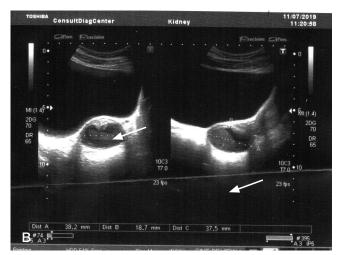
Transabdominal ultrasound examination: A — rudimentary uterine rudiment (transverse scanning); B — the same structure in longitudinal scanning
